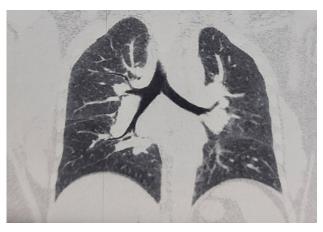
CT showing Hilar adenopathy
